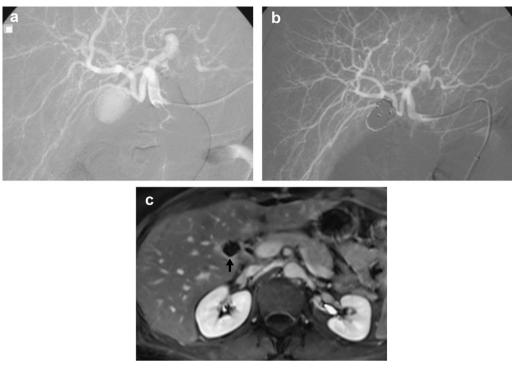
Patient 14: A 41-year-old woman presented three weeks after laparoscopic cholecystectomy with right upper abdominal pain and haemobilia. (a) Selective hepatic arteriogram demonstrating a pseudoaneurysm of the cystic artery stump. (b) Control angiography after coil embolisation of the aneurysmal sac across the neck using the packing technique showing complete occlusion of the false aneurysm and preservation of the main and distal hepatic artery. (c) At 6 months, control magnetic resonance imaging demonstrated total occlusion of the arterial lesion and normal enhancement of the liver parenchyma, without infarction.
